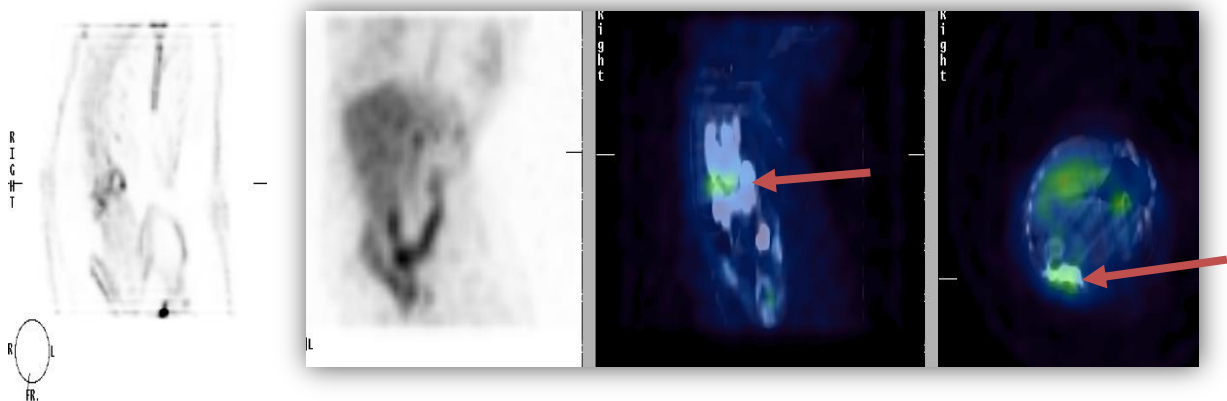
Planar and SPECT/CT images of 30 year old female known with scoliosis , had spinal surgery with orthopedic hardware in 2004, complain of chronic back pain, the planar demonstrate equivocal finding due to overlap with bowel activity . On SPECT/CT this uptake localised to bone and was interpreted as spatially discordant with MDP uptake in keeping with OM.
